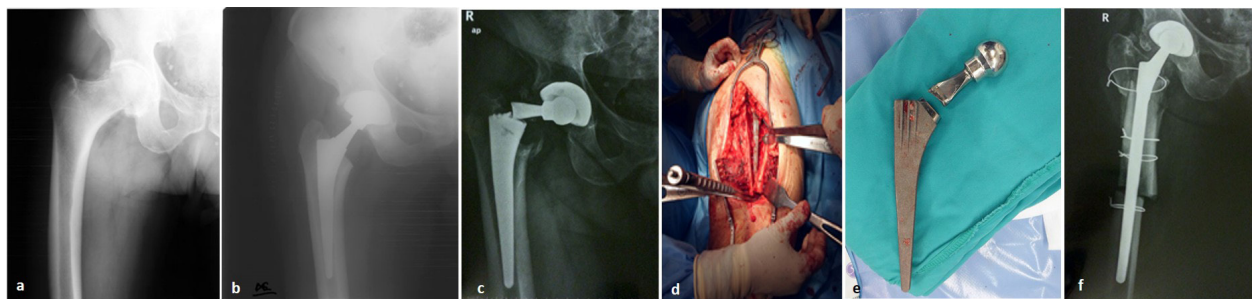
(a) preoperative x-ray of a 64-year-old patient with hip osteoarthritis, (b) 15-days postoperative x-ray after THA implantation, (c) fracture of the femoral neck at 6 years postoperatively, (d,e) intraoperative photos of the extended osteotomy and the broken implant, (f) 3-month postoperative x-ray after revision surgery with a Wagner type stem.
